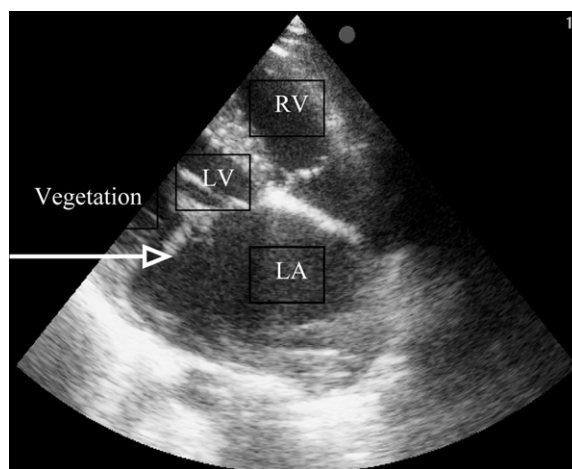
Transthoracic echocardiography in apical 4-chamber view shows mitral valve vegetation. RV, right ventricle; LV, left ventricle; LA, left atrium.
